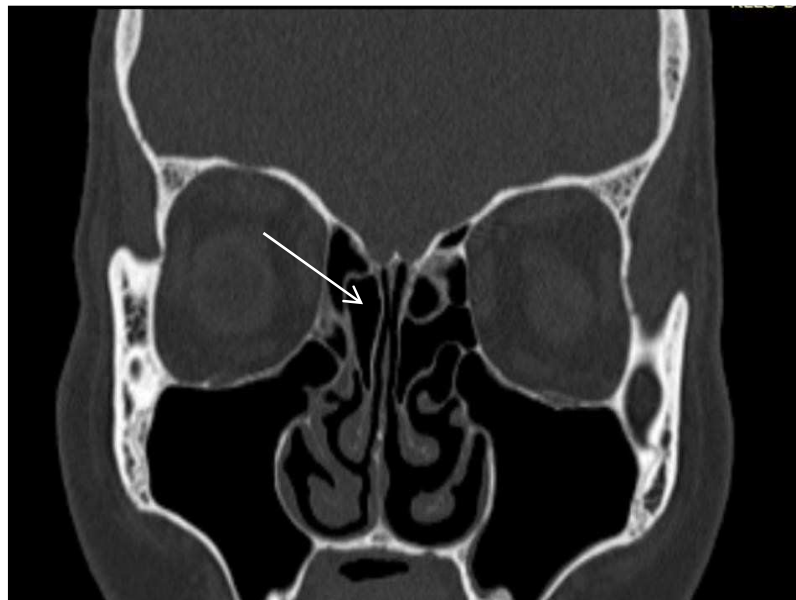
CT PNS Coronal view (Bone window), a) Bilateral Haller Cells and b) Right concha lamella
